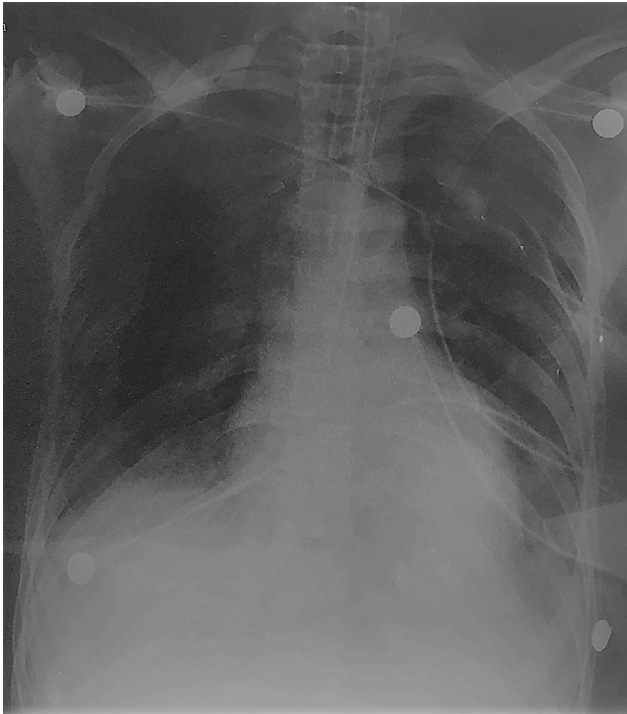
Patient 2 - chest X-ray.
